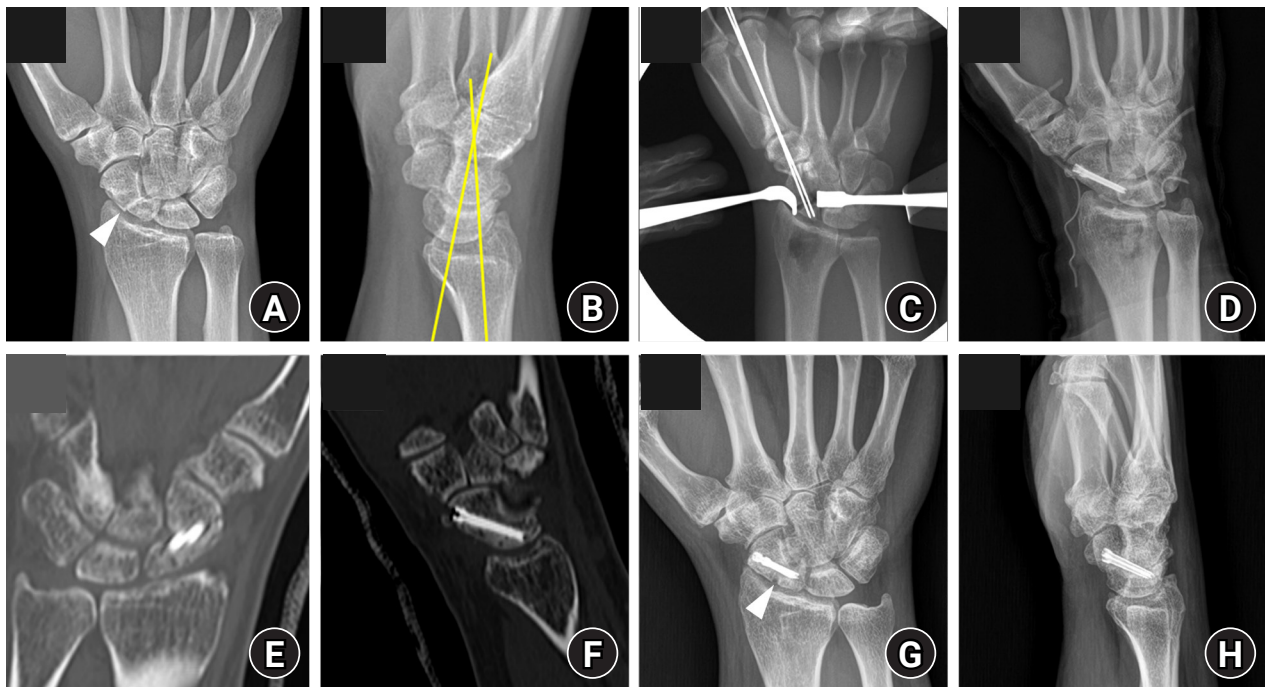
Imaging course of case 2. (A) Initial posteroanterior radiograph showing proximal scaphoid nonunion; the arrowhead indicates the fracture line. (B) Initial lateral radiograph demonstrating DISI deformity; the yellow lines indicate a radiolunate angle of 15.3°. (C, D) Intraoperative fluoroscopic images showing guidewire placement followed by dual 2.4-mm short-thread headless compression screw fixation through a volar approach. (E, F) Follow-up computed tomography obtained 7 weeks after surgery. Coronal and sagittal reconstructed images aligned with the scaphoid axis demonstrate satisfactory intraosseous positioning of the two 2.4-mm screws and adequate purchase of the proximal fragment. (G, H) Radiographs obtained 7 months after surgery show union without loss of alignment or hardware failure; the arrowhead in (G) indicates bridging callus at the nonunion site.
